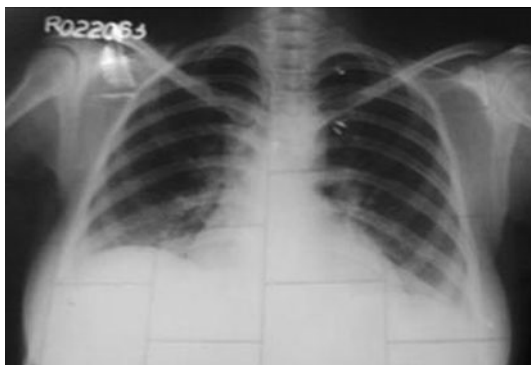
X-ray chest P/A—increased bronchovascular markings
